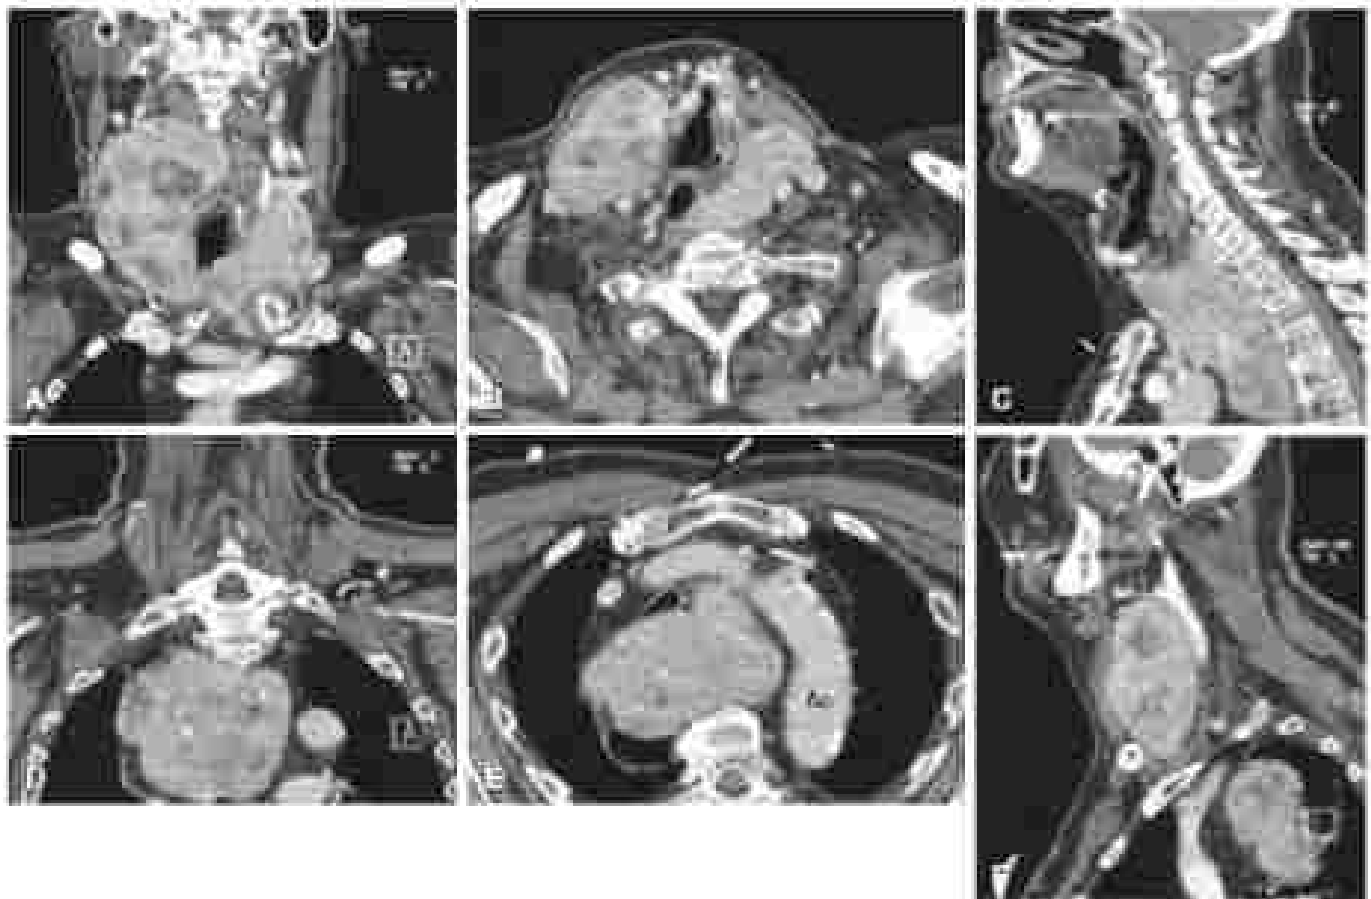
Axial (A–D) and coronal (E) computed tomography (CT) scans with a palpable right thyroid mass. This patient presented with a large palpable right neck mass. Cross-sectional imaging revealed a heterogeneous enhancing enhancing multinodular goiter (A–B) with a retrotracheal and thyroid mass (C–D). Note that the retrotracheal component extends along the arch of the aorta (E) and has grown along the posterior border (C). The right upper pole has displaced the course of the right common carotid artery (F). This patient required resection to define the retrotracheal component of the gland body.
